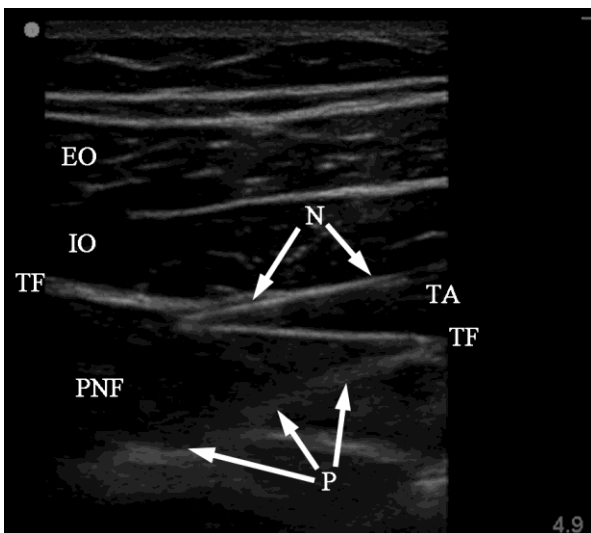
Sonogram at commencement of the TFP injection, showing needle (N), transversus abdominis muscle (TA), transversalis fascia (TF), peri-nephric fat (PNF), peritoneal reflection (P), internal oblique muscle (IO) and external oblique muscle (EO). The needle is positioned through the “tail” of the transversus abdominis muscle
